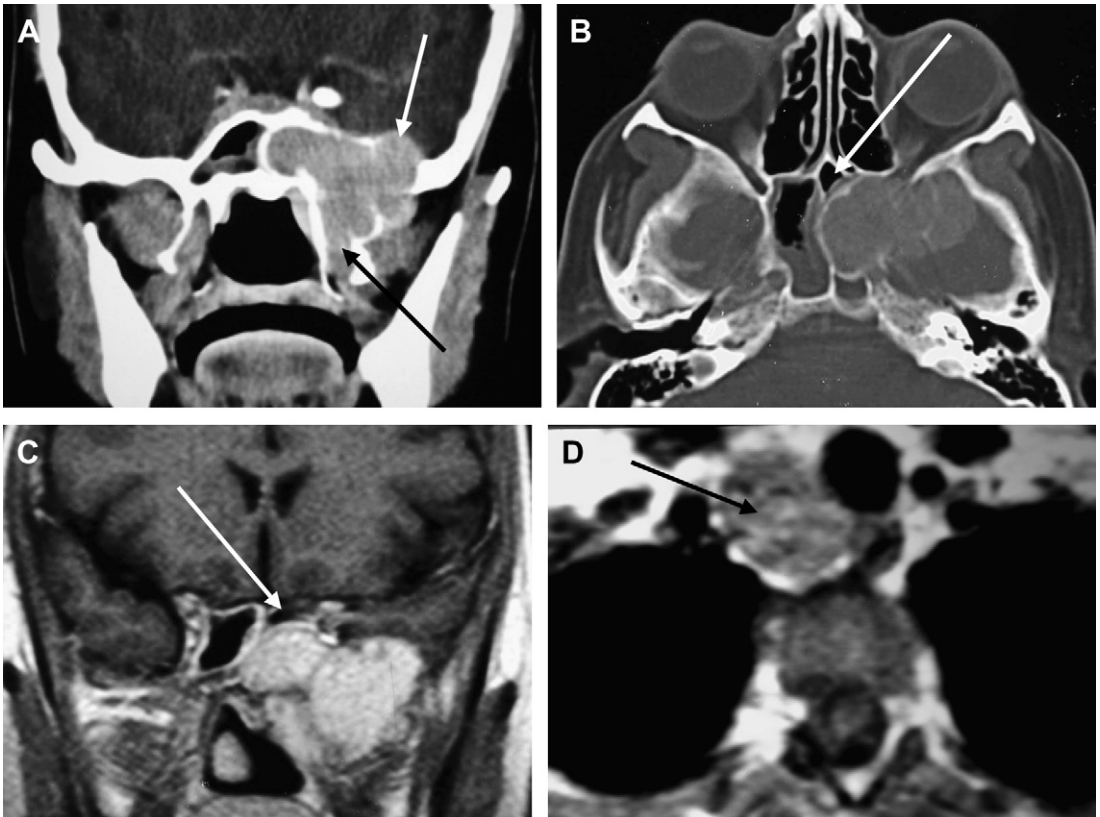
Contrast-enhanced coronal CT image on soft tissue (A), axial CT image on a bone algorithm (B), and coronal postgadolinium MR imaging (C) demonstrate a well-defined expansile lesion centered in the greater sphenoid wing, bulging medially into the sphenoid sinus (partially obliterated by the lesion) (*white arrows in B and C*), bulging superiorly into the middle cranial fossa (*white arrow in A*), and bulging inferiorly into the pterygoid plates (*black arrow in A*). Note the bone remodeling and thinning without frank bone erosion, suggesting a slow-growing benign process. (D) Axial T1-weighted image through the lower neck shows a rounded mass lesion on the right tracheoesophageal groove immediately below the inferior pole of the right thyroid lobe (*black arrow in D*) (brown tumor attributable to primary hyperparathyroidism).
